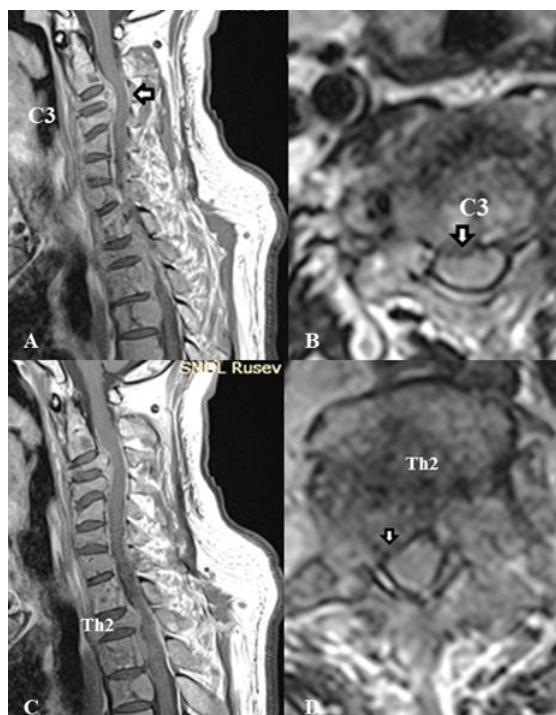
MRI images of multiple spinal metastases:
